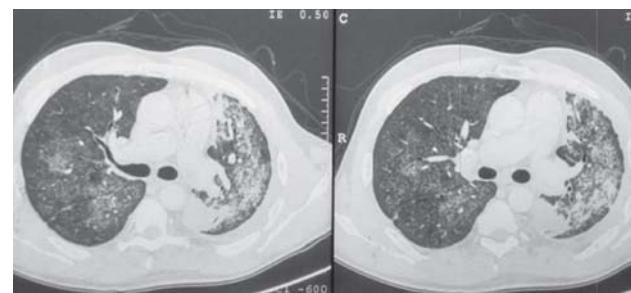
Computed tomography of chest showing patchy areas of ground-glass haze with septal thickening in the left lung, suggestive of interstitial fibrosis.
